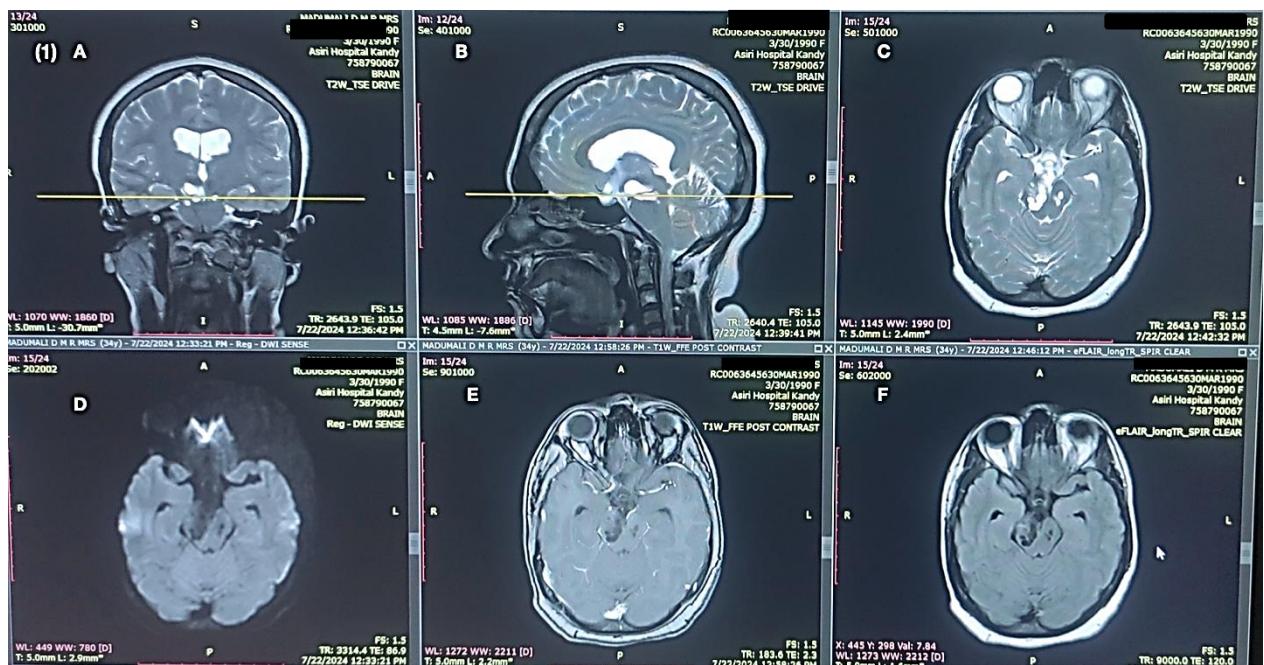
MRI Brain showing abnormal signal intensity in Right basal ganglia, bilateral thalami, midbrain and Pons
